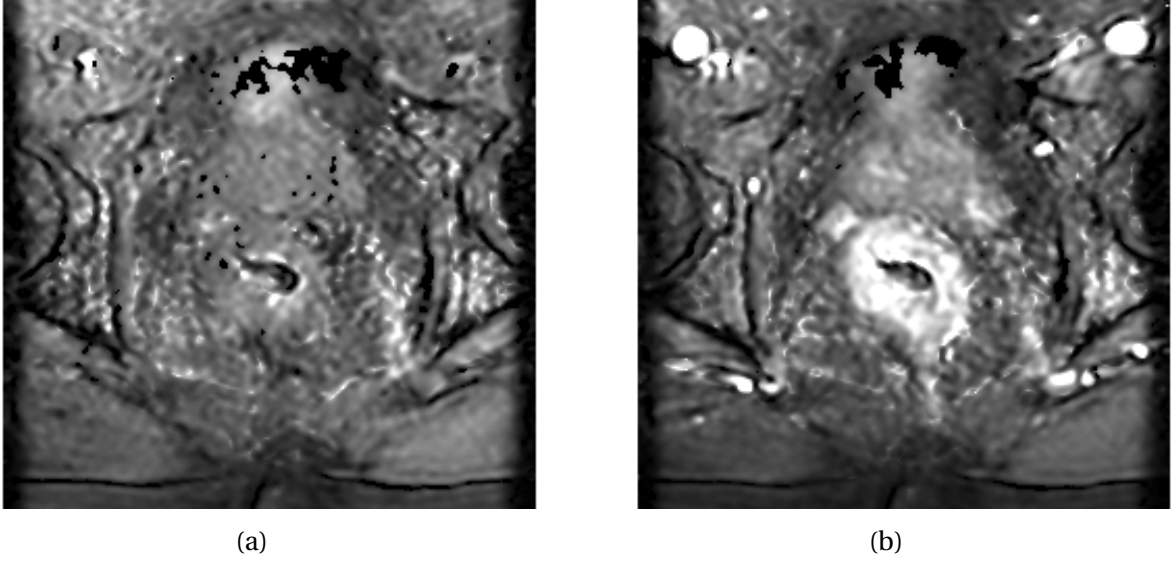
An example of a DCE-MR image, before (a) and after (b) injection of contrast agent. In the centre of the second image the tumour can be seen, enlightened due to an increased uptake of contrast agent in the tumour compared to the normal tissue. The bright circular shapes in the upper corners are arteries, which appear bright because there is a high concentration of contrast agent in the blood. The images are from the Oxytarget study.
